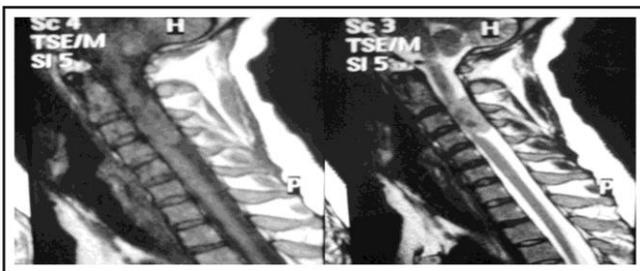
MRI cervical spine T1 weighted & T2 weighted images showing a neurofibroma at the C3-4 level. (Images included with the consent of the patient).
